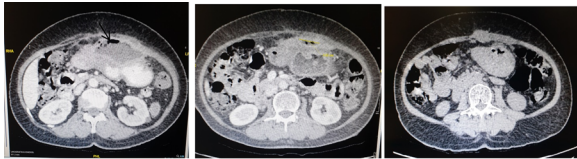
A) Initial CT scan showing an extra luminary mass with a size of 10.13 x 2.98 x 3.89 cm. B) Second CT scan showing reduced size of the mass to 3.02 x 1.45x 0.8 cm. C) Latest CT scan showing a complete resolution of the mass.
